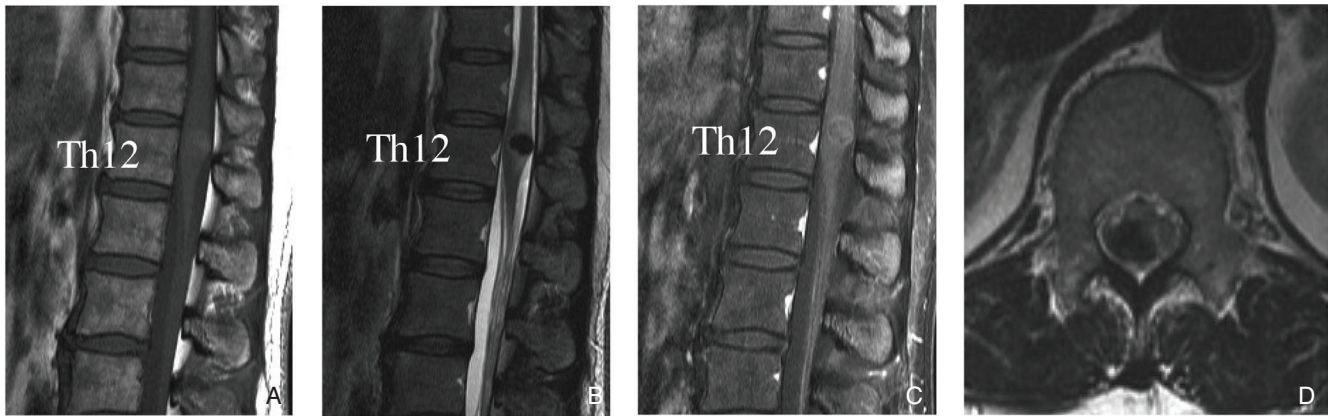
A: Preoperative T₁-weighted sagittal MRI shows a hyperintense lesion at T12 level. B: Preoperative T₂-weighted sagittal MRI shows a hypointense lesion at T12 level. C: Preoperative T₁-weighted sagittal MRI with gadolinium enhancement reveals the homogenous enhancement of the lesion. D: Preoperative T₂-weighted axial MRI demonstrates an intradural extramedullary lesion that displaced the spinal cord anteriorly. MRI: magnetic resonance imaging.
